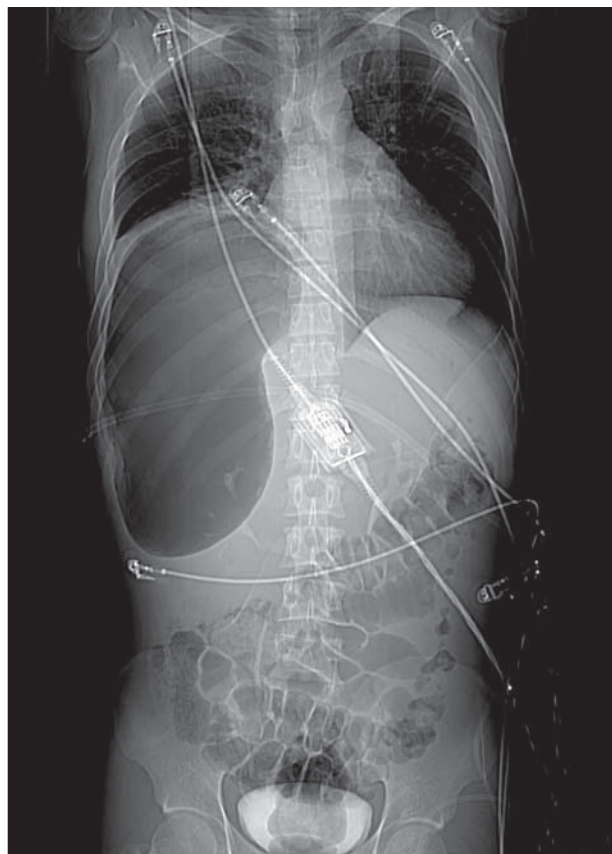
Scouting computed tomographic scan.
